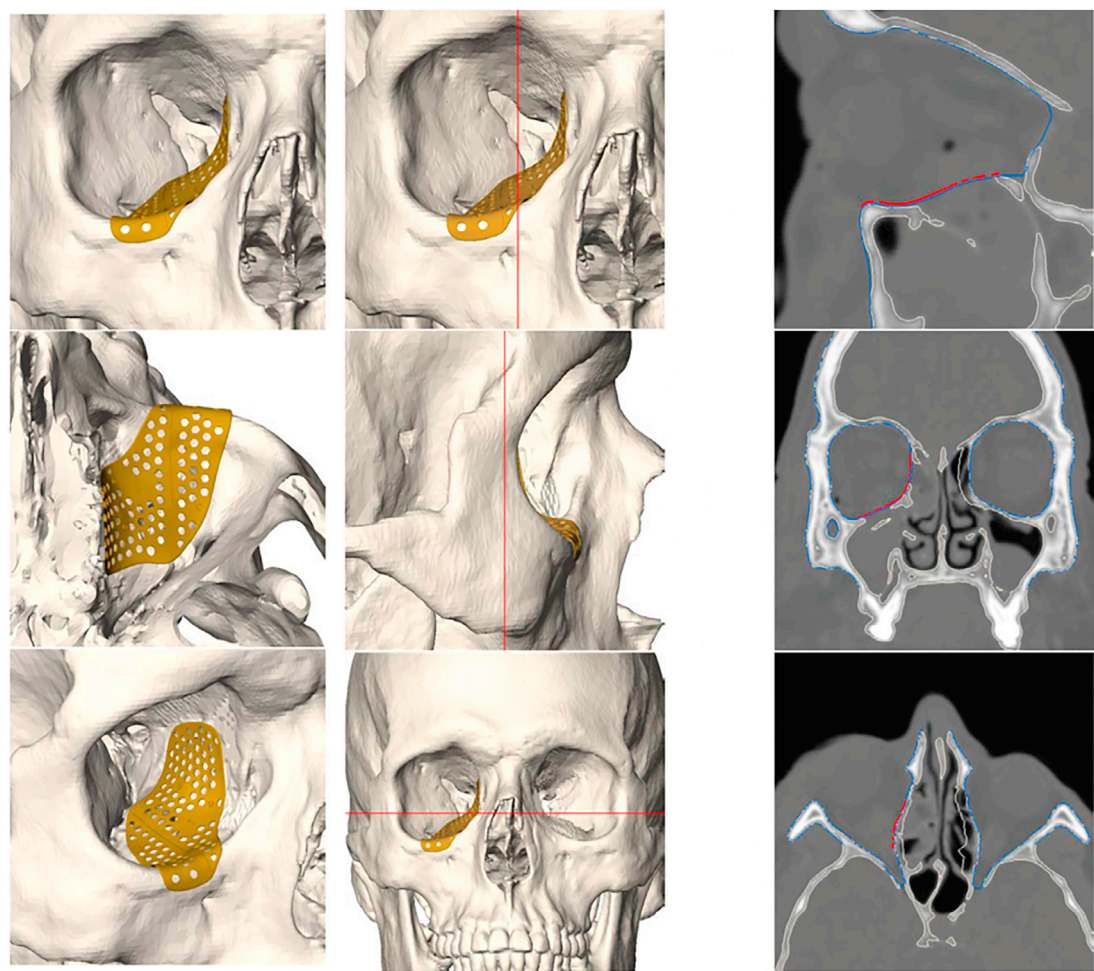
VSP with PSI for a fracture involving the orbital floor and medial wall. The implant consists of titanium mesh 0.3 mm in thickness with two screw holes and a sterile bony host model. Measurements are mapped based on preoperative CT images in sagittal, coronal, and axial planes as well as 3D models. The sagittal view demonstrates the anatomic S shape of the orbital floor.
